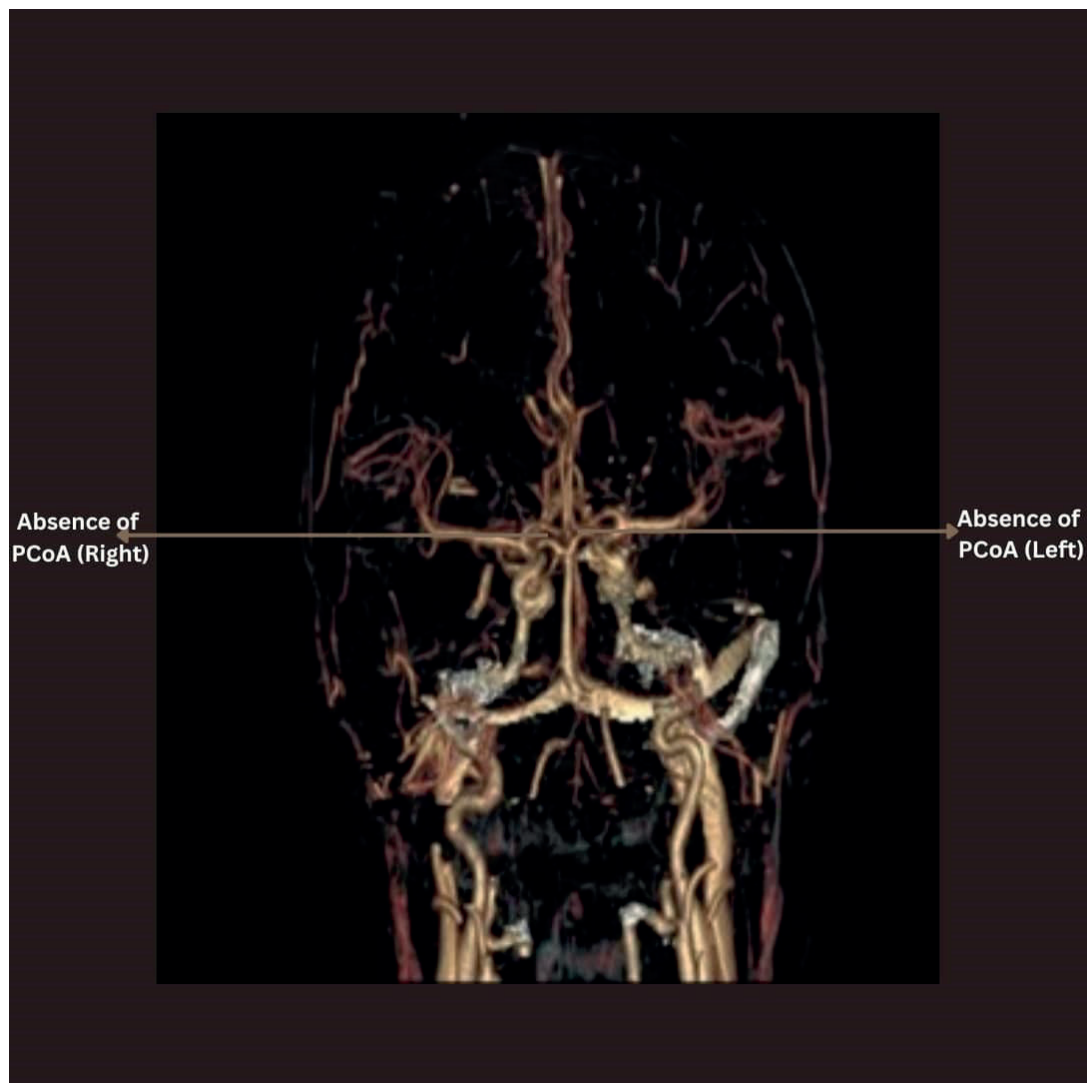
Volume Rendered (VR) CTA image of the circle of Willis showing bilateral absence of PCoA.
